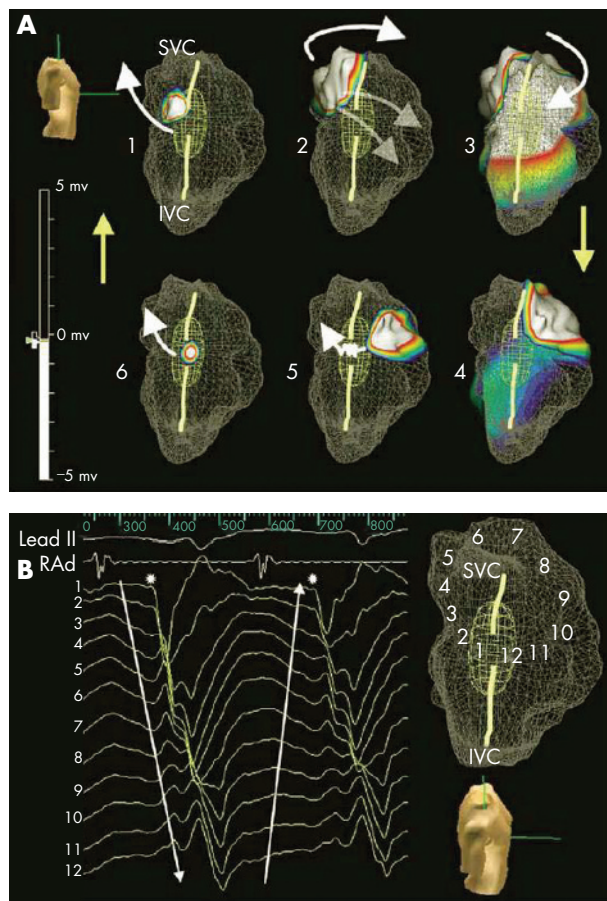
(A) Upper loop re-entry circuit with the superior vena cava and functional conduction block along the crista terminalis acting as the central obstacle. A computer generated reconstruction of the right atrial (RA) endocardium ("virtual endocardium") with isopotential maps superimposed, recorded during atrial tachycardia using non-contact mapping (EnSite, St Jude Medical). The right atrium is seen from the right lateral view in all frames (torso indicates orientation) and the inferred position of the crista terminalis (CT) depicted by a yellow line. During sinus rhythm activation progressed across the upper part of the CT from anterior to posterior. Conduction block was demonstrated by programmed atrial stimulation from the medial aspect of the chamber at a cycle length of 300 ms. Isopotential maps generated from non-contact unipolar electrograms during arrhythmia demonstrate activation (white arrow) exiting from a gap in the CT and ascending the posterior wall superiorly towards the superior vena cava and medially to the atrial septum (frame 1). The wave front proceeds around to the anterior wall (faded white arrow), with the orifice of the superior vena cava (SVC) acting as the superior turning point, before returning to the gap in the crista terminalis (frames 2–4) which acts as a narrow corridor of slow conduction (zig-zag arrow) (frame 5), prior to re-emerging on the posterolateral wall to complete the circuit (frame 6). (B) Non-contact unipolar electrograms depicting atrial activation during tachycardia. Electrograms from lead II, the distal bipole of a right atrial catheter (RAD) and virtual unipolar electrograms recorded during the tachycardia shown in panel A. The right atrium is seen from a right superolateral aspect (torso indicates orientation) to expose the SVC orifice and demonstrate the upper turning point of the circuit. Electrograms recorded at 12 points (1–12) around the circuit are demonstrated. Activation onset at point 1 is depicted by QS morphology on the unipolar electrogram (*) and rotates in an anti-clockwise direction to point 12. The orifice of the SVC and the upper part of the CT appear to act as the central obstacle. Reprinted with permission from: Abrams D, Schilling R. Mechanisms and mapping of atrial arrhythmia in the modified Fontan circulation. *Heart Rhythm* 2005;2(10):138–44.
